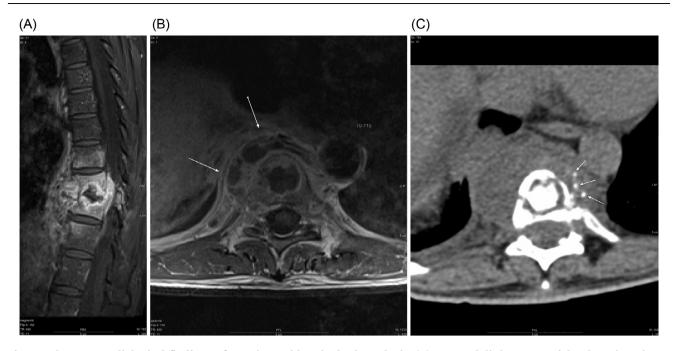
The neuroradiological findings of a patient with spinal tuberculosis. (A) Post-gadolinium T1-weighted MR imaging with fat saturation, sagittal view, showed enhancement of the T9 and T10 vertebrae with apposing endplates erosion, and enhancing soft tissue spreading along the anterior subligamentous space, from T7 to T12 level. Mild enhancement of the T8 inferior and T11 superior vertebral bodies are also noted, but the T8/9 and T10/11 discs are preserved. (B) Post-gadolinium T1-weighted MR imaging with fat saturation, axial (at T9–10 level) view, showed extensive paraspinal abscess (arrow). (C) CT scan of the thoracic spine axial view showed calcification of the paraspinal abscess (arrow).
